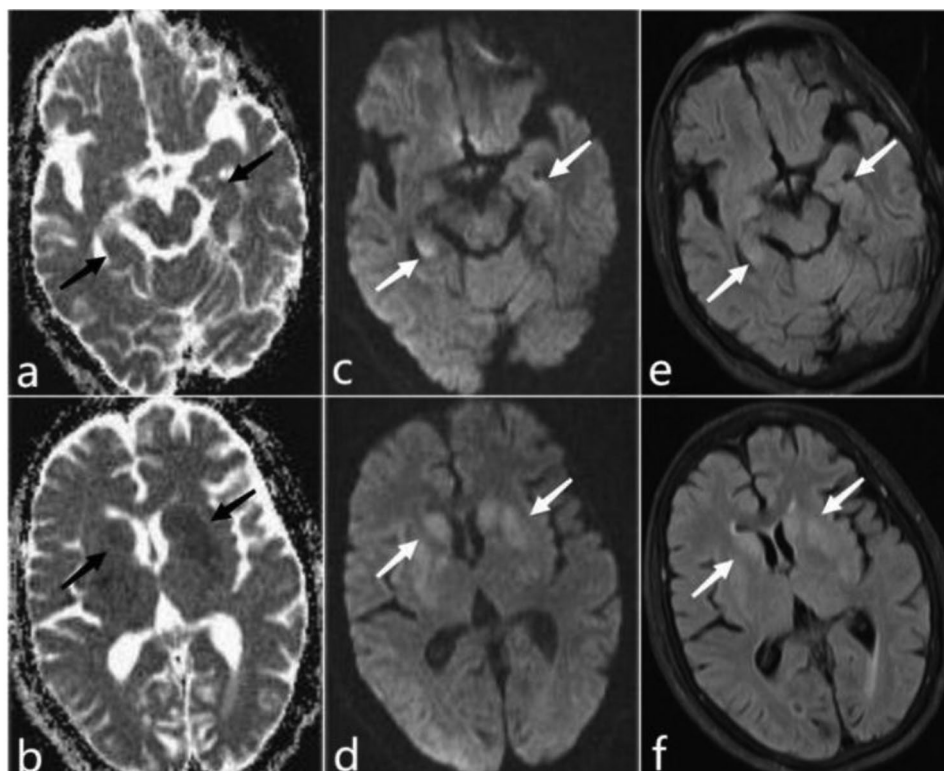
Panels a and b show low signal changes in the bilateral basal ganglia and hippocampal regions on ADC (Apparent Diffusion Coefficient) images (black arrows); Panels c and d show high signal changes on DWI (Diffusion Weighted Imaging) (white arrows); Panels e and f show slightly high signal changes on FLAIR (Fluid-Attenuated Inversion Recovery) images (white arrows)
